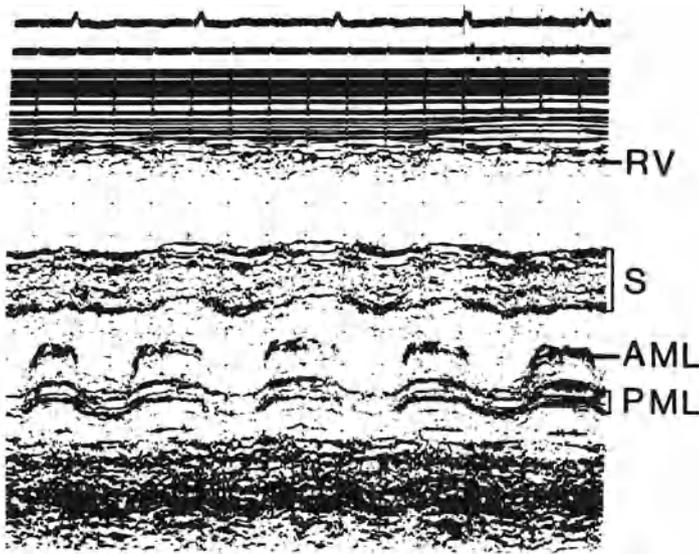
Echocardiogram of the mitral valve showing severe mitral stenosis in an elderly patient with no auscultatory evidence of mitral stenosis (compliments of Dr. Howard Wayne, Sharp Memorial Hospital, San Diego, California). RV = right ventricular wall, S = septum, AML = anterior mitral leaflet, PML = posterior mitral leaflet.
